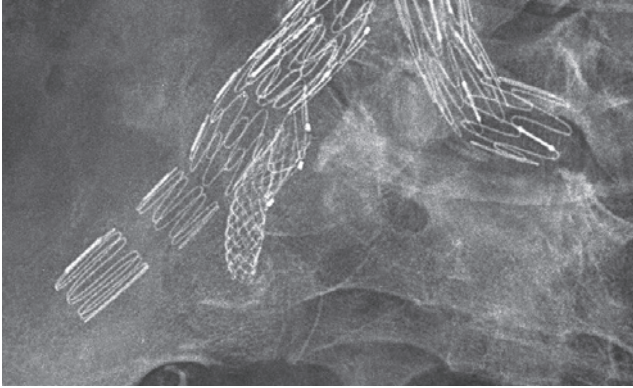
Detail of plain radiograph of the abdomen in left anterior oblique projection shows iliac branched device on the right side with stent-graft bridging the side arm with the internal iliac artery.
